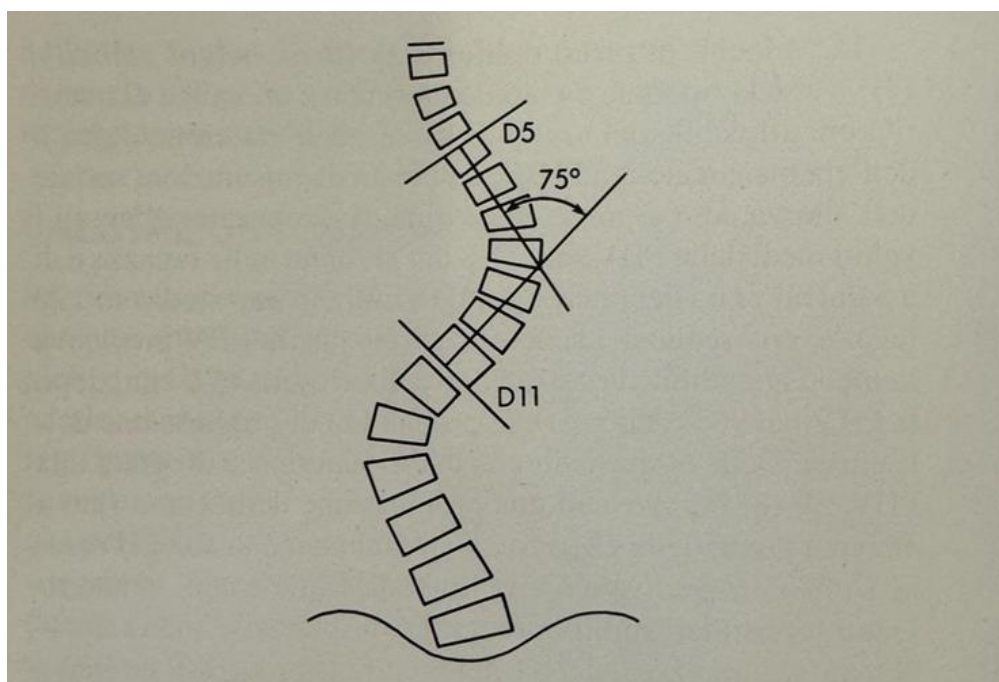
Radiographic measurement of Cobb Angle.
